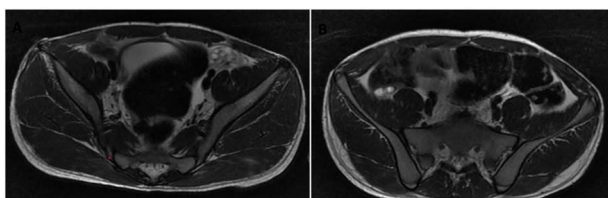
Magnetic resonance imaging (MRI) (transversal section) showing the left (A) and the right (B) ovary.
